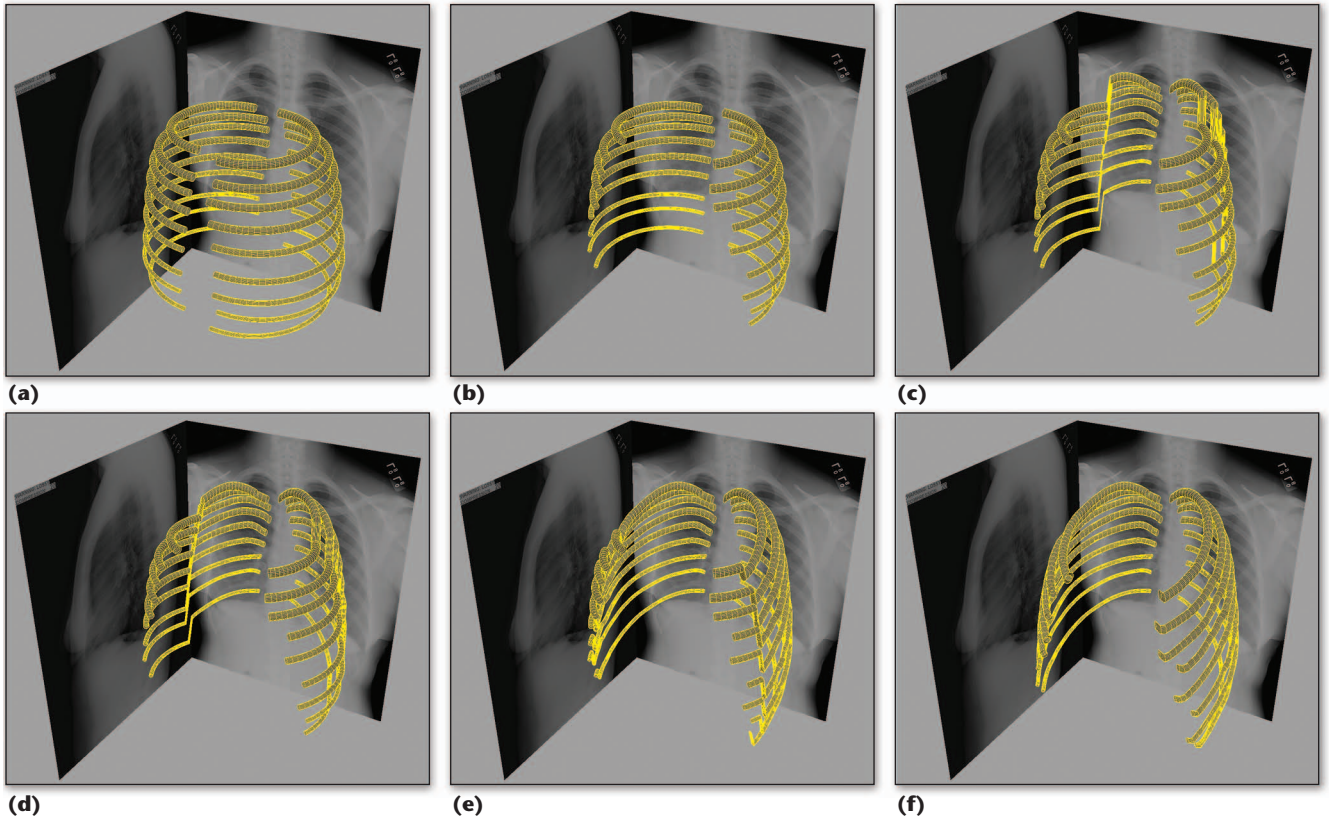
The initial pass of the radial-vertex-cluster transformation: (a) the initial rib templates, (b) rib templates with extra vertices removed from the end of the anterior section, (c–f) radial clusters translated vertically to align with the segmentation at different stages of this process. This shows the process of transforming the rib template to match the segmented ribs from the PA x-ray image.
